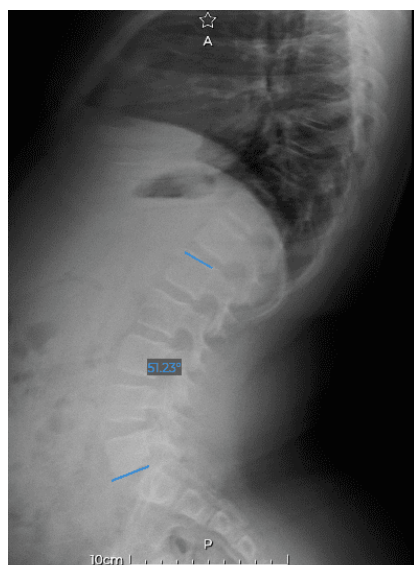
Lumbosacral X-ray of patient showing lumbar hyperlordosis with Cobb angle at 51.23°
